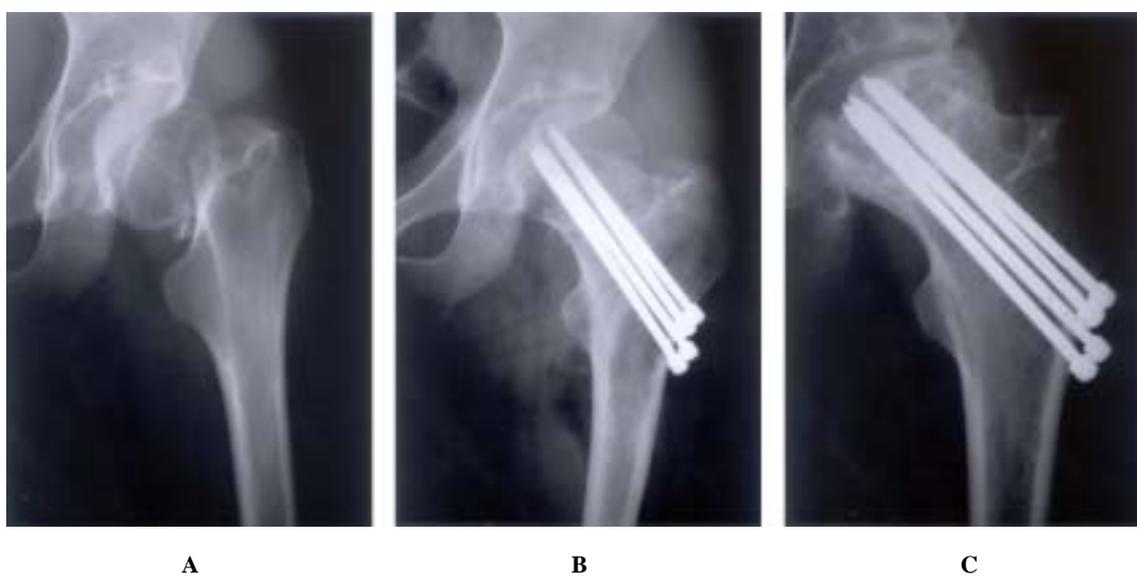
Preoperative radiograph of 25 years old female patient showing Lt. femur neck fracture of Garden stage 4.
